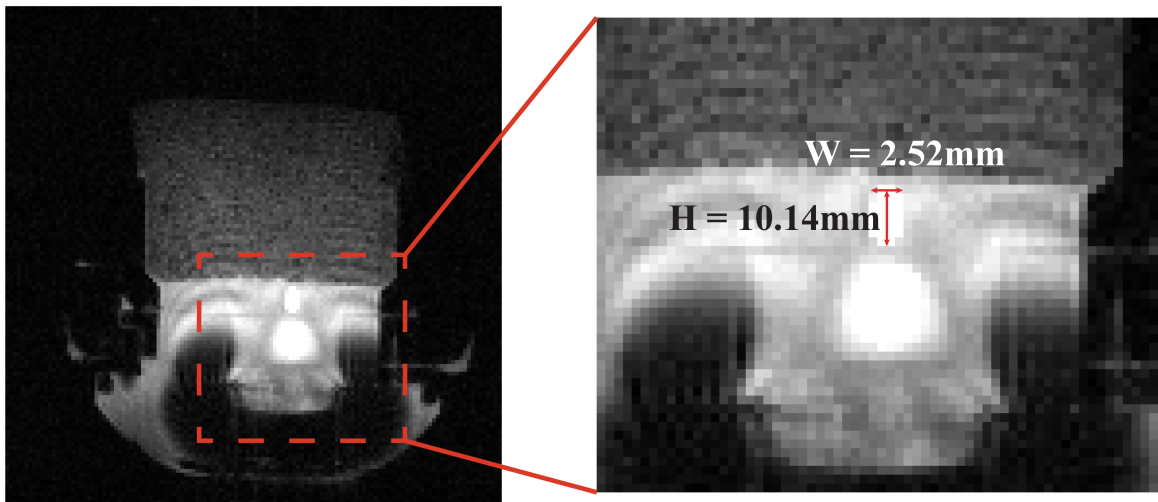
MRI Scan of focus generation during sonication.
